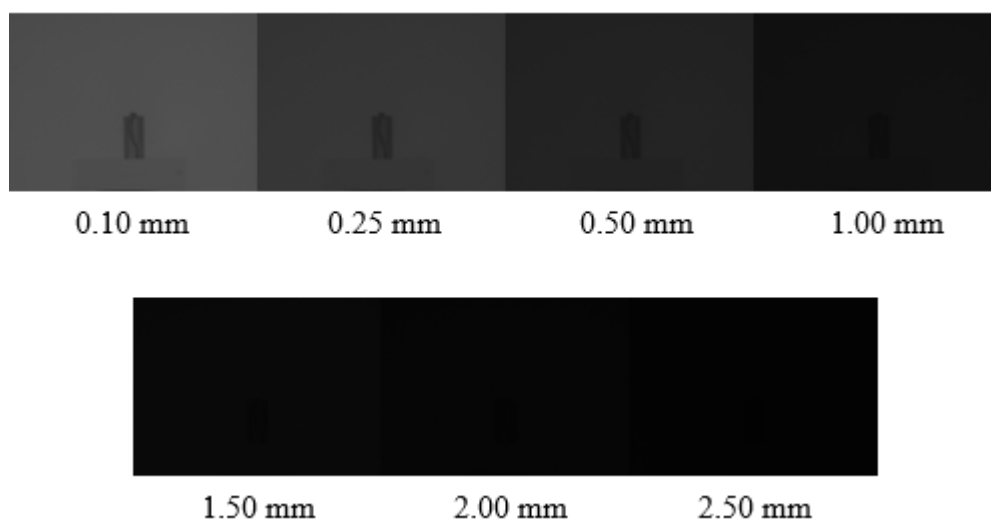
Typical radiographs that were acquired within the copper filter thickness range of 0.1 mm – 2.5 mm, X-ray current of 100 μ A, X-ray tube voltage of 100 kV, FSD of 65 cm and X-ray exposure time of 1 sec.
